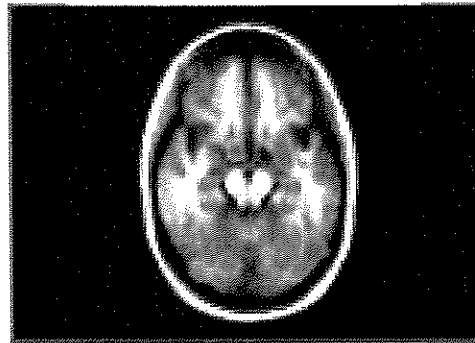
High-resolution magnetic resonance image of normal brain with CAT scan. Source: PBS (2001).
